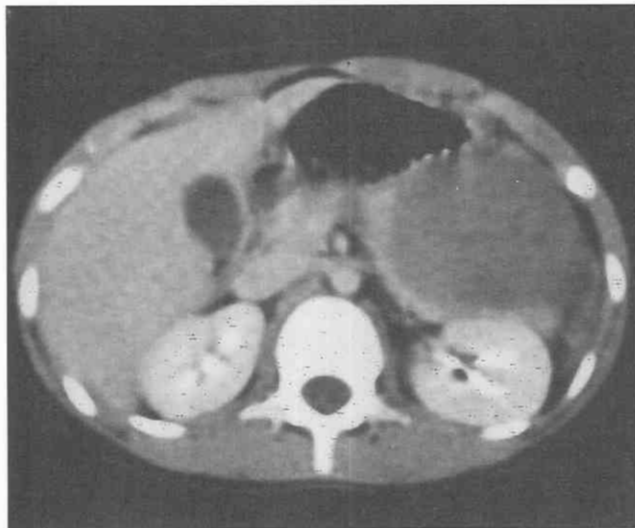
Solid and papillary epithelial neoplasm of the pancreas. CT scan through the pancreas demonstrates a large mass originating in the tail of the pancreas. The mass demonstrates decreased attenuation relative to the pancreatic body and tail.
